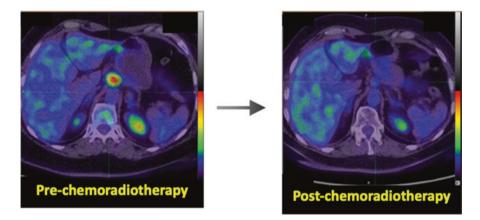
Utility of post-neoadjuvant treatment restaging 18F-FDG PET scan. This patient underwent CROSS protocol neoadjuvant chemoradiation. Baseline PET scan images on the left compared to restaging PET scan 4 weeks following completion of neoadjuvant treatment demonstrates a complete metabolic response of the tumour
